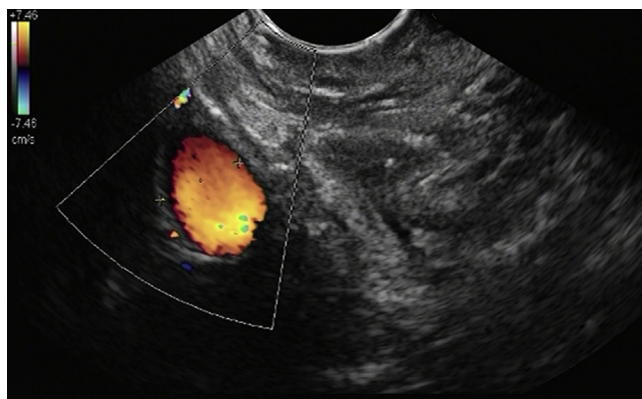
Location of portal vein confirmed by Doppler imaging.
